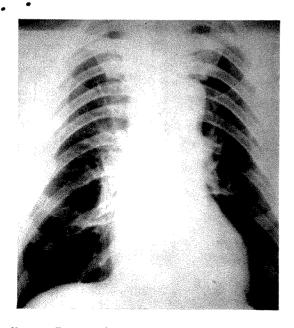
Case 1. After roentgen treatment over four fields, total dose 8,240 r, daily dose 100-200 r.
